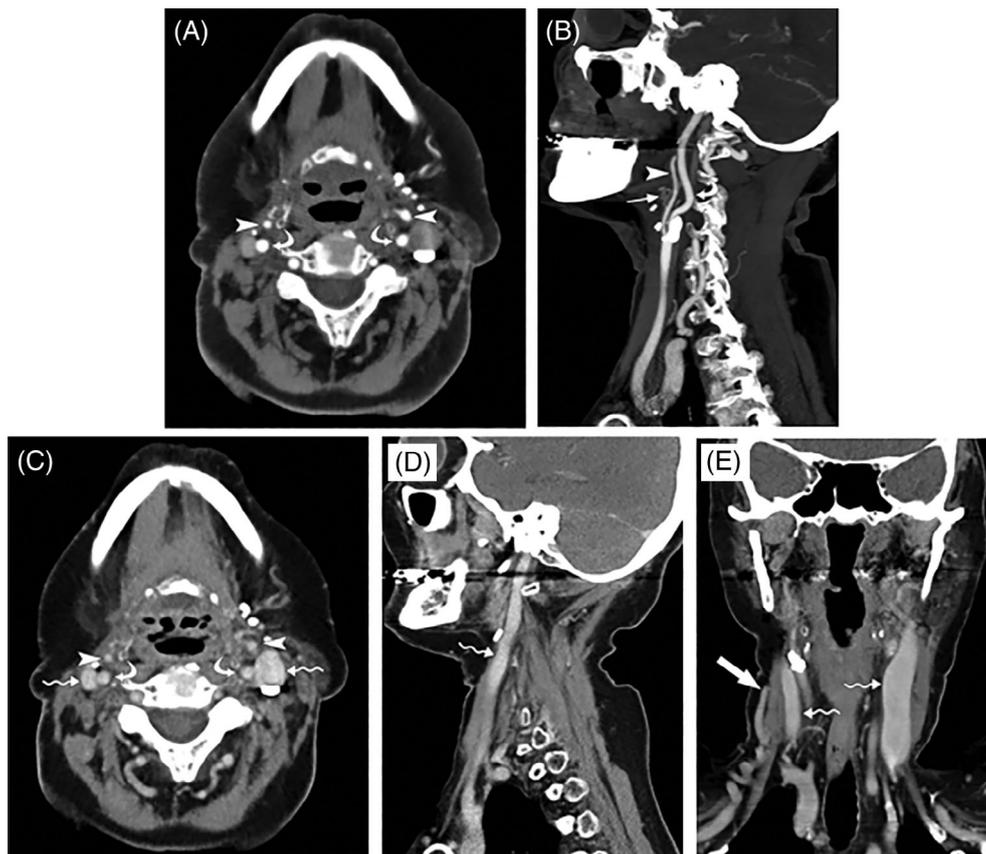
Arterial and venous phases of dual-phase CTA for case B. Axial arterial phase image (A) demonstrates patency of bilateral internal carotid arteries (ICA, curved arrows) and bilateral external carotid arteries (ECA, arrowheads). Right parasagittal thick MIP arterial phase image (B) demonstrates patency of the right lingual artery (thin straight arrow) in addition to normal opacification of the right ICA (curved arrow) and ECA (arrowhead). Axial delayed phase image (C) demonstrates contrast filling of both internal jugular (IJ) veins (wavy arrows), with patency of the right IJ vein confirmed on a parasagittal delayed phase image (D). Coronal delayed phase image (E) demonstrates patency of only the lower half of the right external jugular (EJ) vein (thick arrow). Portions of both patent IJ veins (wavy arrows) can be seen. The left EJ vein and proximal right EJ vein were not visible on any of the delayed phase images
